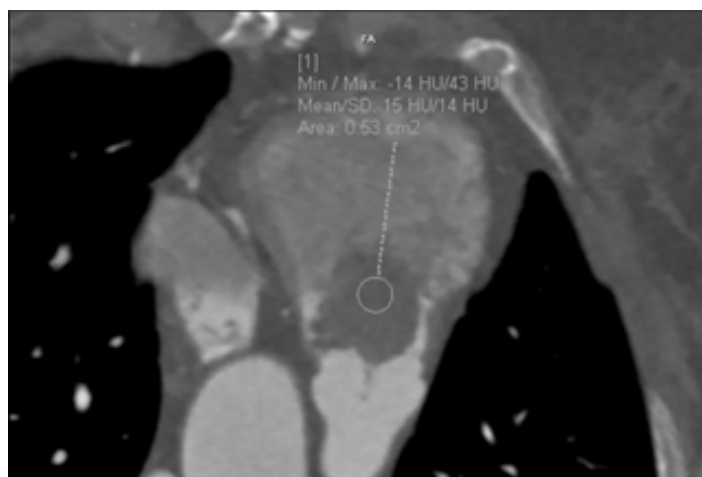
Prospective gated CT coronary angiogram.
